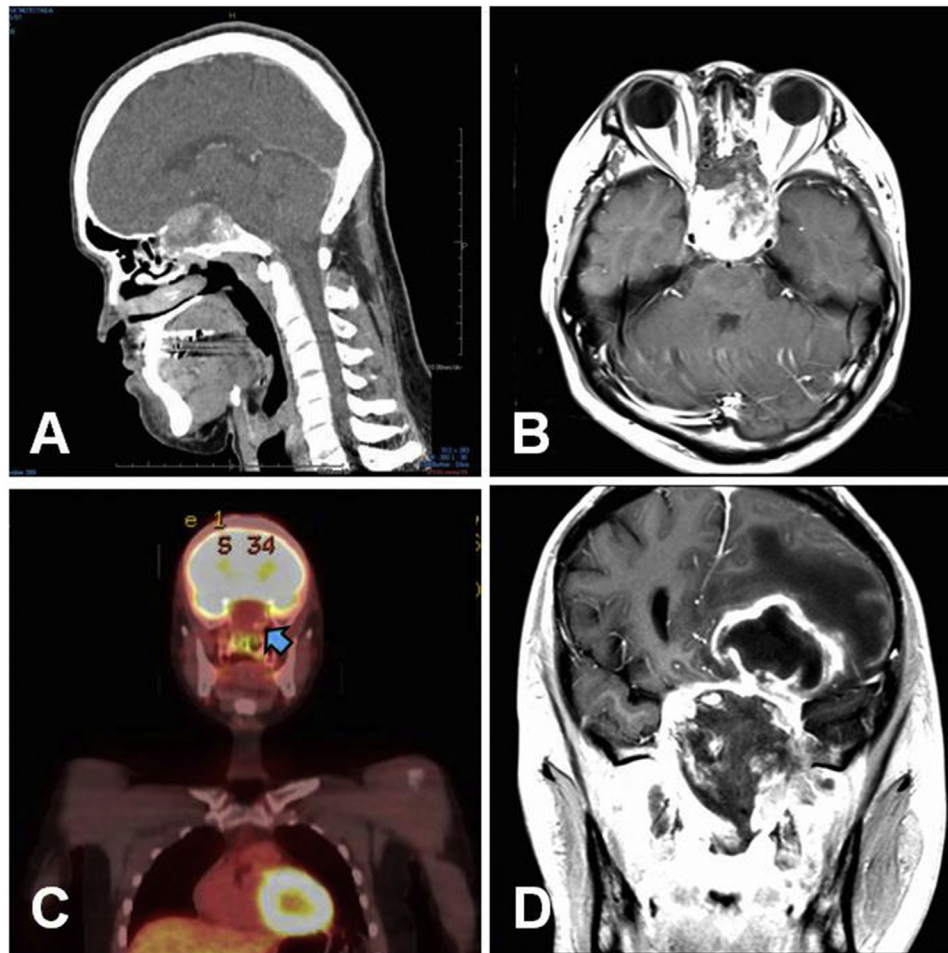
Sagittal computed tomography with bone window showing widespread osteolysis of the middle skull base associated with a mass (A). Preoperative and gadolinium (Gd)-enhanced magnetic resonance imaging (MRI) demonstrating a heterogeneously enhancing mass in the sphenoid sinus and sella turcica (B). After radiotherapy, positron emission tomography demonstrating lower fluorodeoxyglucose (18F) uptake in the residual lesion (C, arrow). Gd-enhanced MRI at 12 months after surgery showing local tumor progression and a left-frontal-lobe abscess (D).
